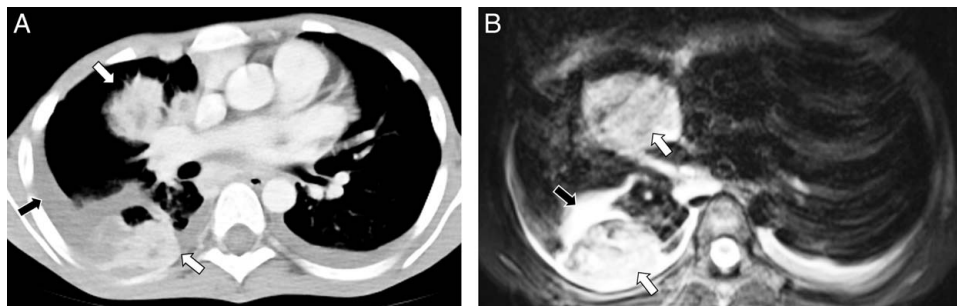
A 12-year-old girl with pleural metastases from hepatocellular carcinoma. A, Axial enhanced soft tissue window setting CT image shows pleural masses (white arrows) and right pleural effusion (black arrow). B, Axial nonenhanced T2-weighted fat suppressed MR image shows pleural masses (white arrows) which are more clearly localized to the pleural space than on CT due to outline by hyperintense right pleural effusion (black arrow).
